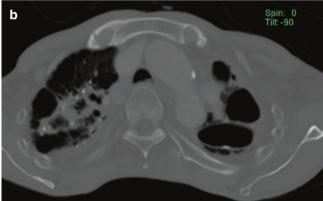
Features of old tuberculosis. (a) Frontal chest radiograph shows extensive bilateral scarring, calcified nodules, volume loss, and pleural calcification (from previous empyema). (b) Axial CT image in the bone window shows calcified lung nodules, surrounding patchy consolidation and destruction of the left upper lobe lung parenchyma with cavity formation
